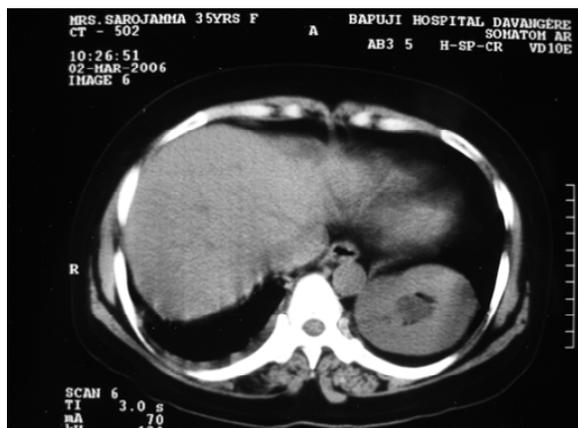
Axial CT scan at Th 9 level shows the left kidney situated in the left posterior inferior thorax
